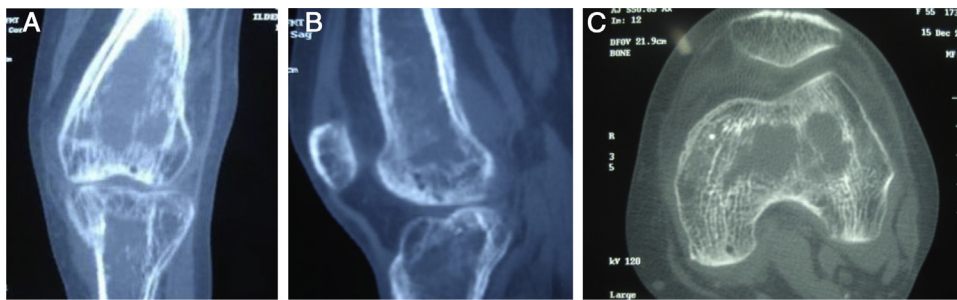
Computed tomography of the left knee, with bone window, showing trabecular osteolysis and periosteal reaction. Coronal (A), sagittal (B) and axial slice (C).
